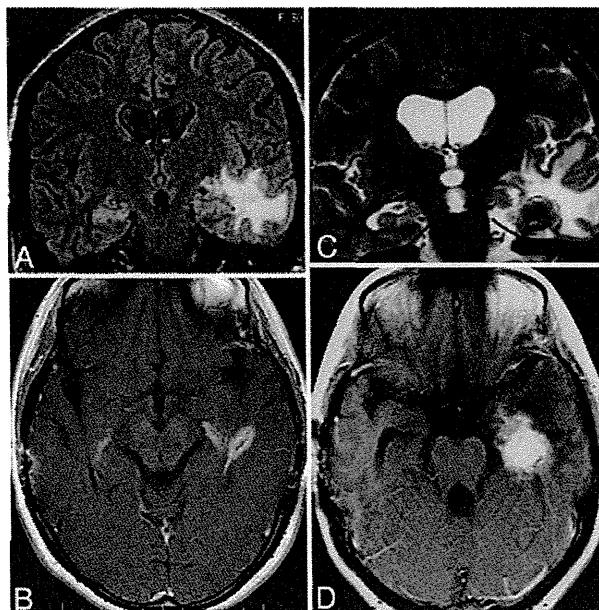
Case 3. Magnetic resonance images. Coronal FLAIR (A) and axial Gd-enhanced (B) images obtained 10 months after GKS showing small areas of edema in the temporal lobe and a Gd-enhanced lesion in the medial temporal lobe. Coronal T2-weighted (C) and axial Gd-enhanced (D) images obtained 5 years after GKS showing augmentation of necrosis in the medial temporal lobe and diffuse edema around the area of necrosis.
